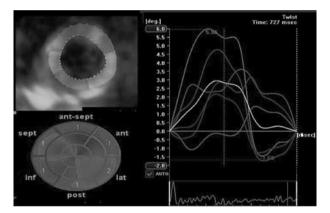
Basal twist values detected by color coded 3-dimensional speckle tracking echocardiography from basal short-axis level of LV (top left) and bullseye plot image (bottom left) and corresponding time-to-strain curves from basal segment sites (right)
